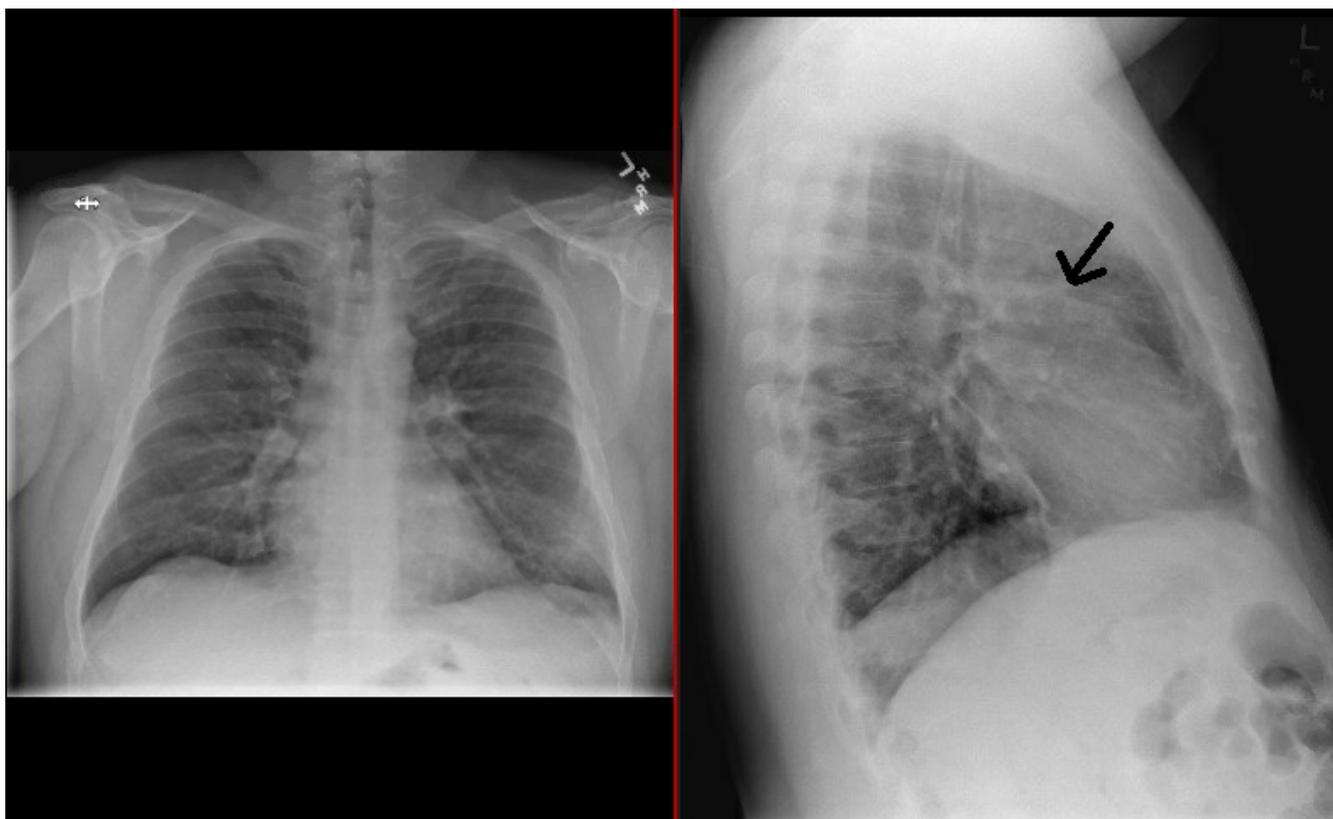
Chest X-ray done prior to hospital admission showed left lower lobe pneumonia.
